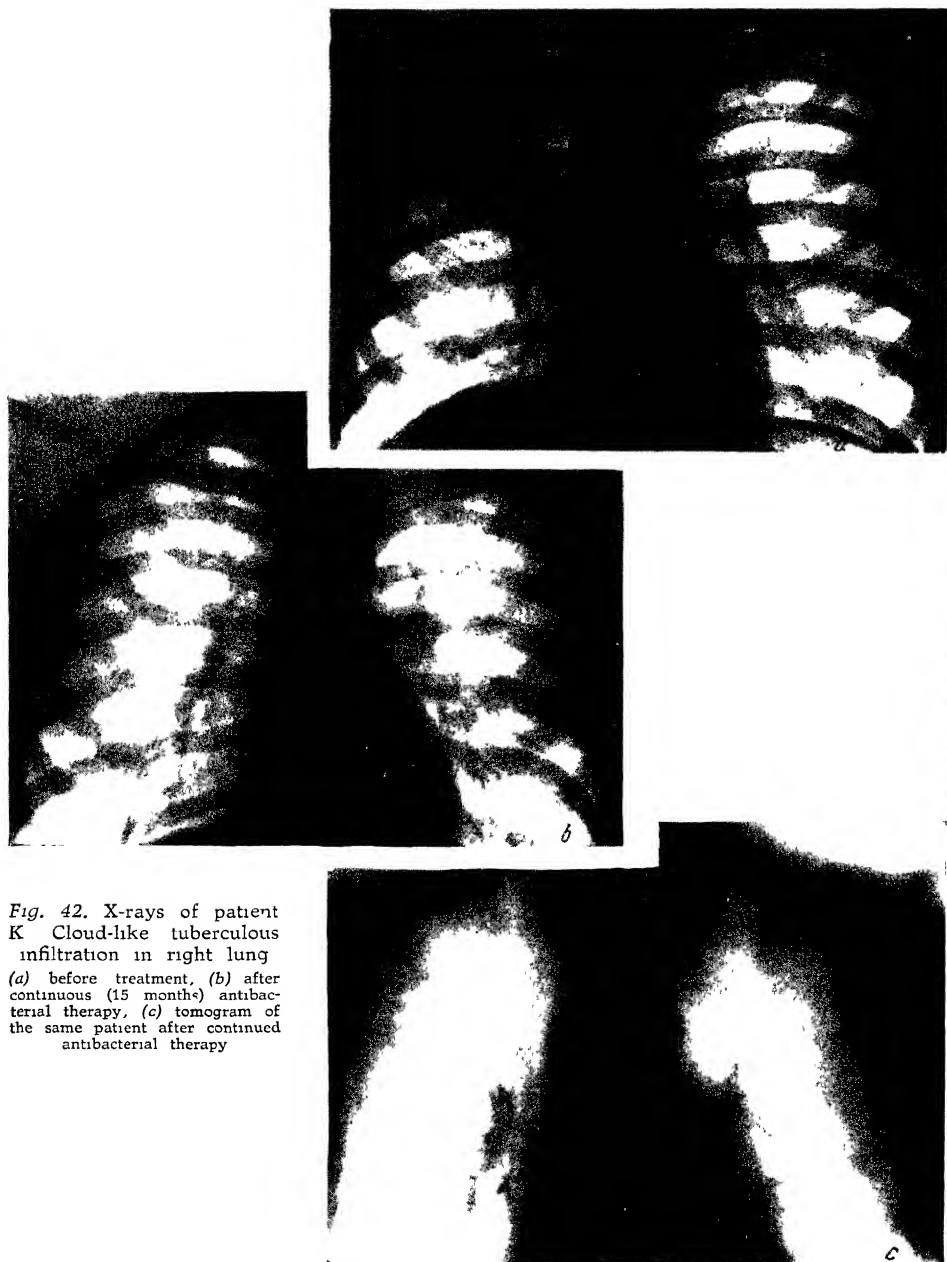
X-rays of patient K Cloud-like tuberculous infiltration in right lung (a) before treatment, (b) after continuous (15 months) antibacterial therapy, (c) tomogram of the same patient after continued antibacterial therapy
